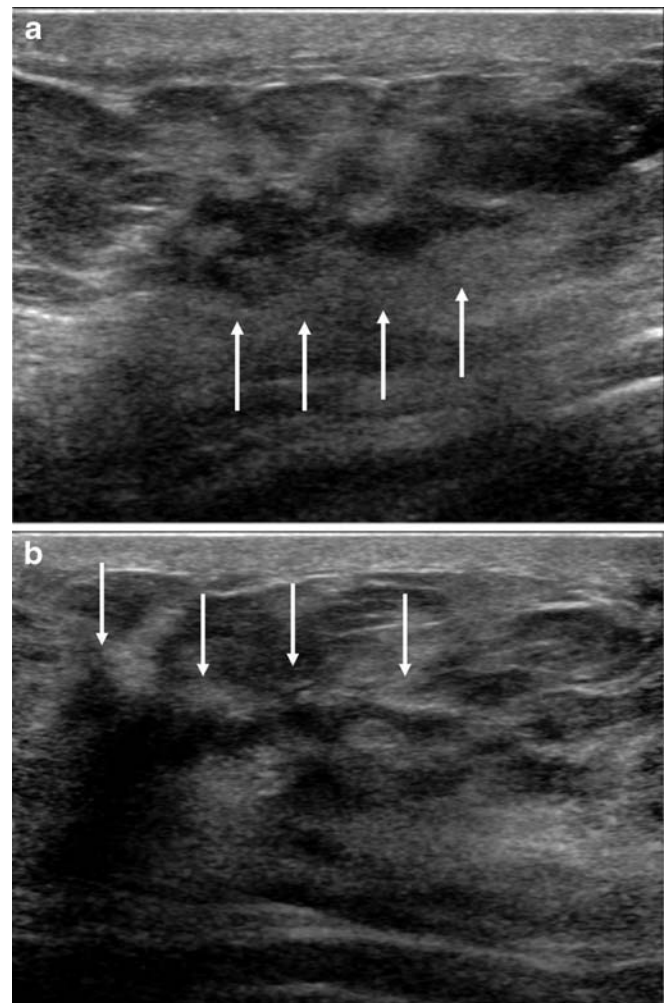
A 37-year-old woman with a palpable lump in the right breast. a and b Orthogonal ultrasound images show an irregularly shaped, heterogeneously echogenic area (arrows) in the right breast. Surgery confirmed the presence of a triple-negative invasive ductal carcinoma
